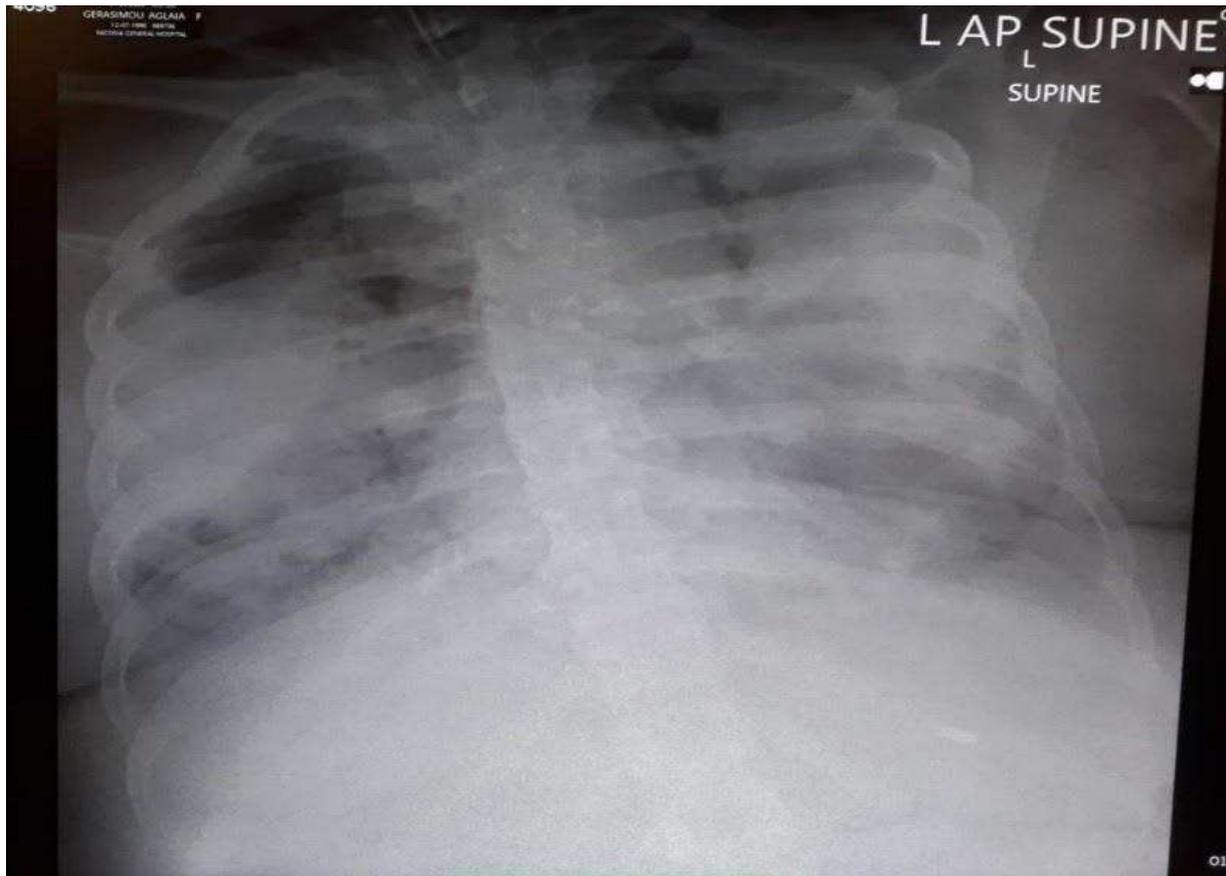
A portable chest X-ray was done and showed diffuse pulmonary infiltrates (air bronchogram densities) with tension in the lower lobes.
